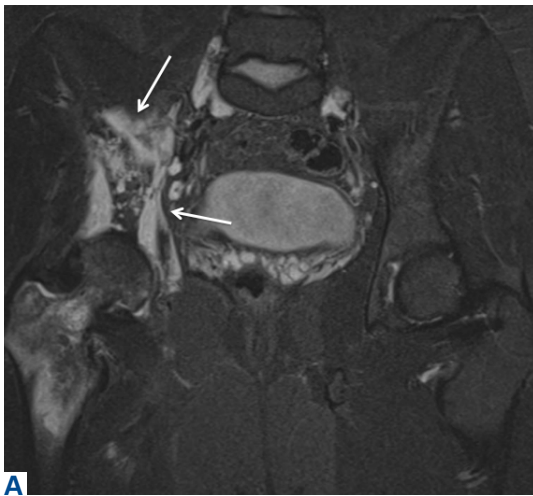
(A) T2-weighted fat-suppressed coronal magnetic resonance imaging (MRI) shows extensive soft-tissue edema enveloping the right iliac bone (white arrows) with pronounced underlying bone marrow edema pattern in the right iliac bone and the proximal femur. (B) Contrast-enhanced MRI shows enhancing soft-tissue surrounding iliac bone laterally, anteriorly, and posteriorly (white arrows), infiltrating the marrow and resulting in osseous destruction of bone around the right sacroiliac joint, as seen on computed tomography (CT). Material from this area was subsequently aspirated under CT guidance and found to be serosanguinous; cultures of the aspirate were negative for bacteria and atypical organisms.
